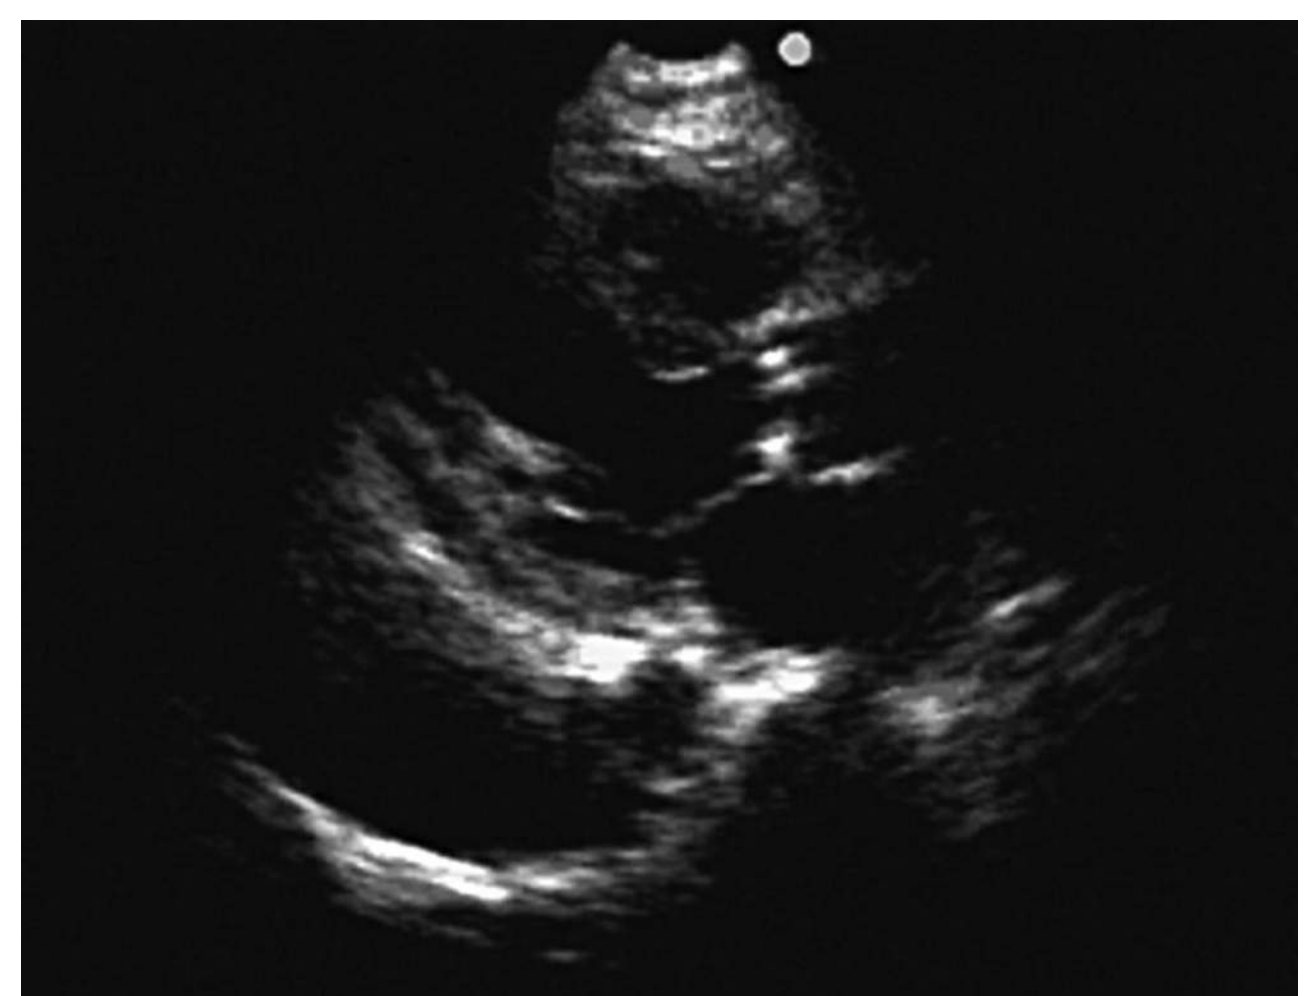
Parasternal long-axis view showing a large pleural effusion with an anechoic fluid stripe layering out posterior to the left ventricle and descending aorta. Compare this image with Figure 53-16 to see the difference between locations of a pericardial and pleural effusion.
